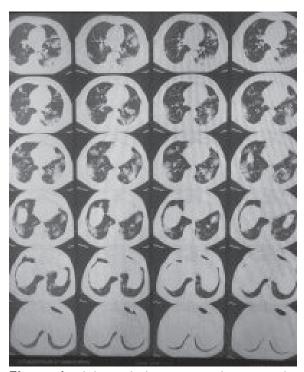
High resolution computed tomography (HRCT) scan of chest showing multiple ground glass density involving 40% of lung volume
